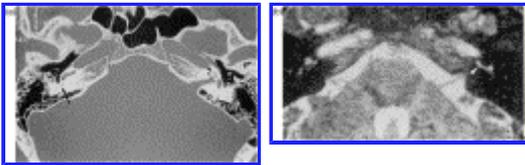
Fibrosis versus calcification. Bilateral post-meningitis labyrinthitis. (a) HRCT shows a left calcified apical and mesial turns (arrowhead) and obliteration of the posterior semicircular canal (arrow). (b) T2WI shows a bilateral decrease of the high signal of the posterior membranous labyrinths. Remaining patency of the left stenotic basal turn (arrowhead).
